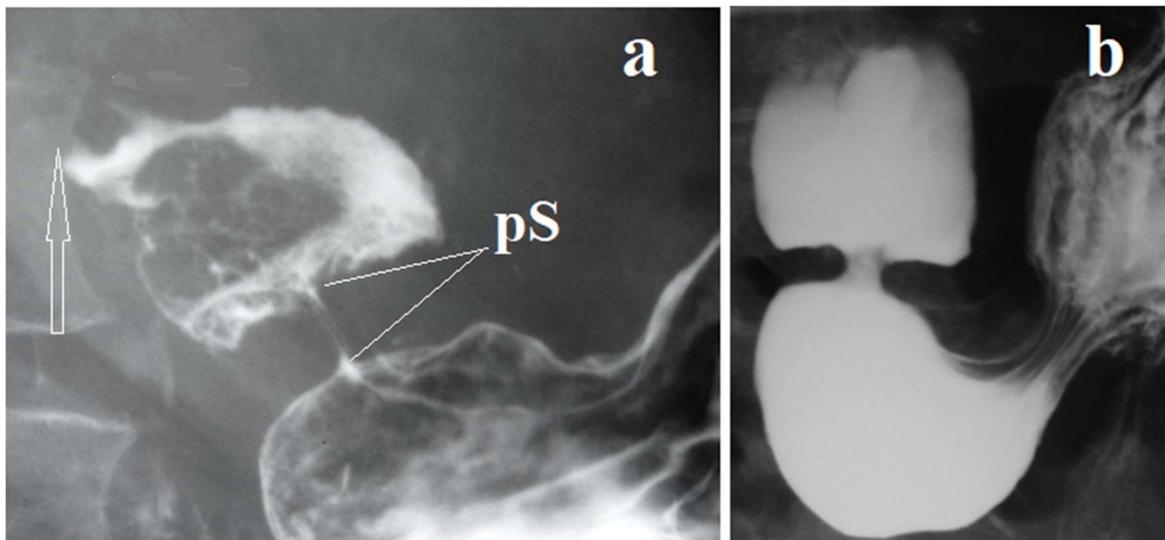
Radiographs of the gastro-duodenal junction. (a) The pyloric sphincter (pS) is in a closed state. The arrow indicates the location of the contracted post bulbar sphincter. The width of the bulbus base is almost equal to that of the opposite side of the stomach. (b) At the moment of evacuation of barium from the stomach, the pS widened and its length decreased.
